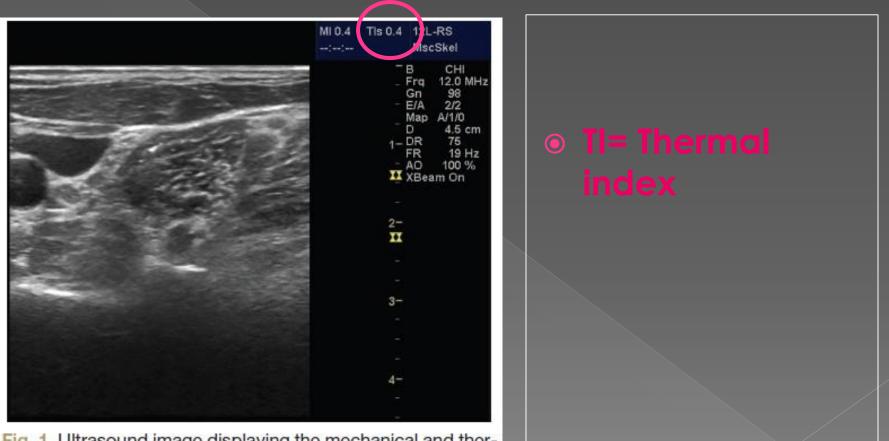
Ultrasound image displaying the mechanical and thermal indices as MI and TIs, respectively. In this image the indices are displayed at the top right corner. The location may vary depending on the manufacturer.
